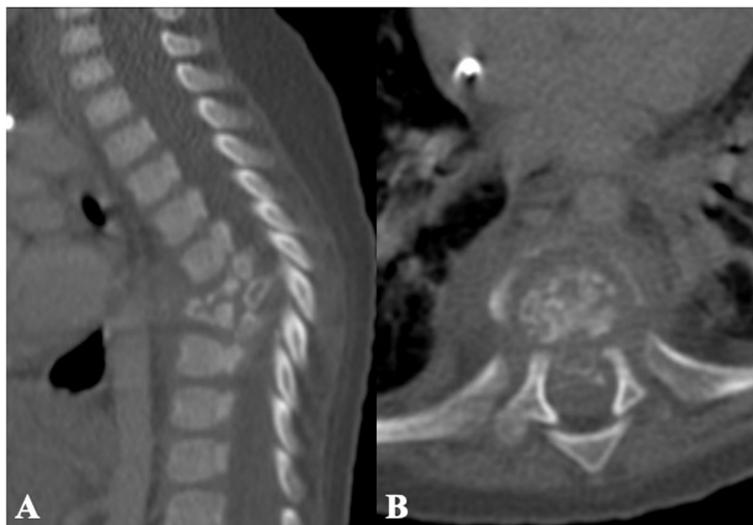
Dorsal CT scan in bone window, the vertebral destruction of D7 and D8 is observed in A sagittal view and B axial view
